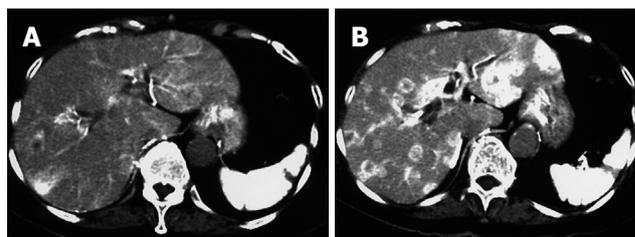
A 78 years old woman with liver metastasis from pancreatic cancer. A: Conventional angiographic CT; B: Phramacoangiographic CT with angiotensin II. The tumor to liver contrast is increased, and well demarcated low density area in the liver is now highly indicative of liver metastasis.
